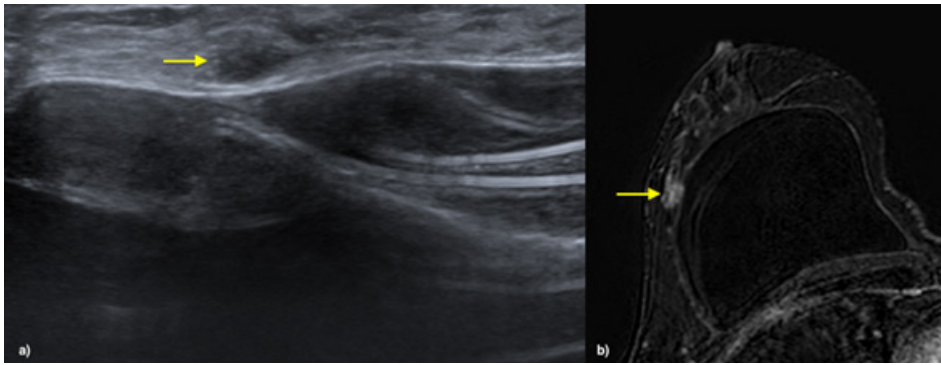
The same ultrasound study (Figure 15) also revealed the presence of a nodule with indeterminate ultrasound characteristics, and a complementary MRI study was performed. In the study of MR (b), this presented enhancement after administration of contrast, and a directed biopsy was performed, which revealed that it was a foreign body granuloma.
